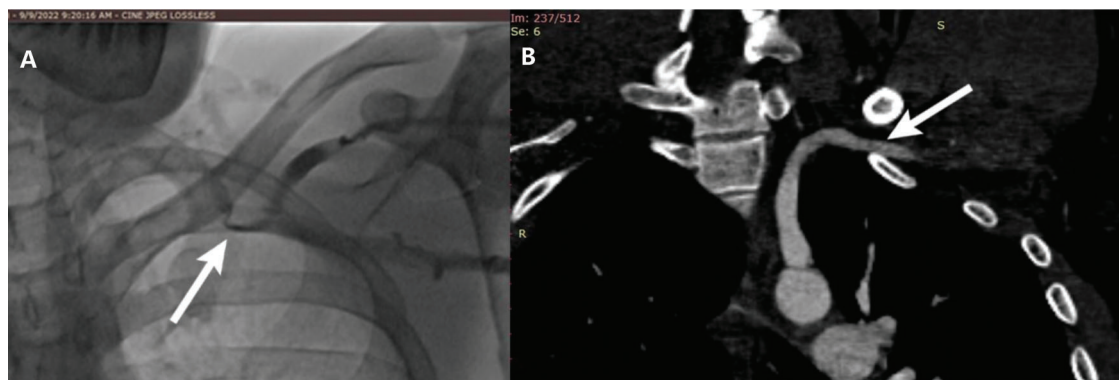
Presence of intramural thrombosis - Imaging techniques: A) Preoperative venography reveals the presence of intramural thrombosis along with extraluminal compression situated medially between the left clavicle and the first rib; B) Postoperative CTA incorporating venogram demonstrates a complete expansion of the subclavian vein observed five months after the surgical intervention.
